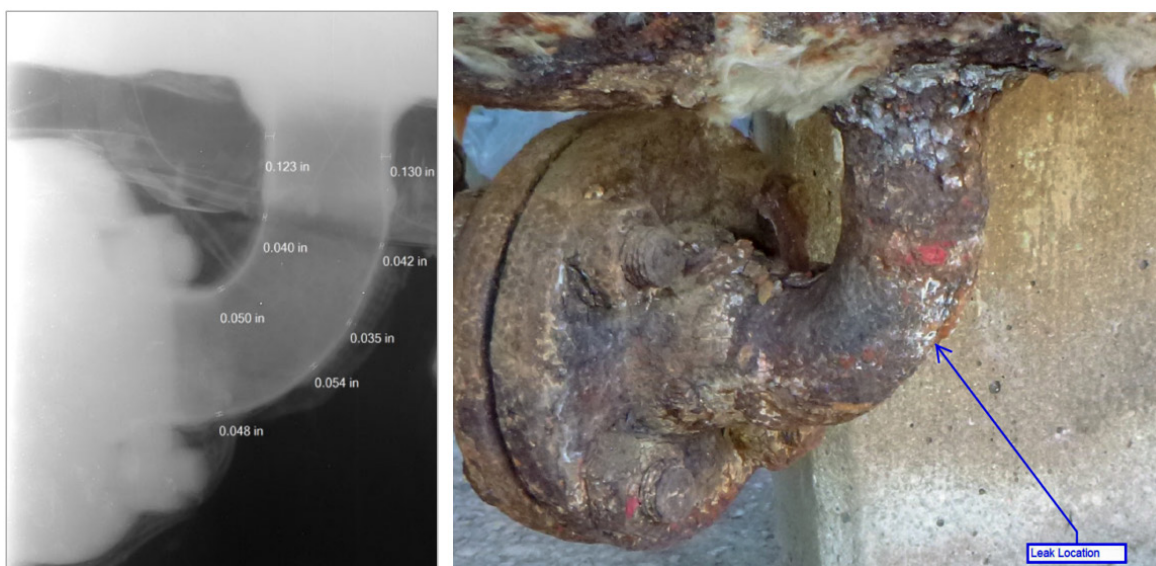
Pre-incident x-ray (left) and photo (right) of the drain piping. (Credit: PBF Energy)
